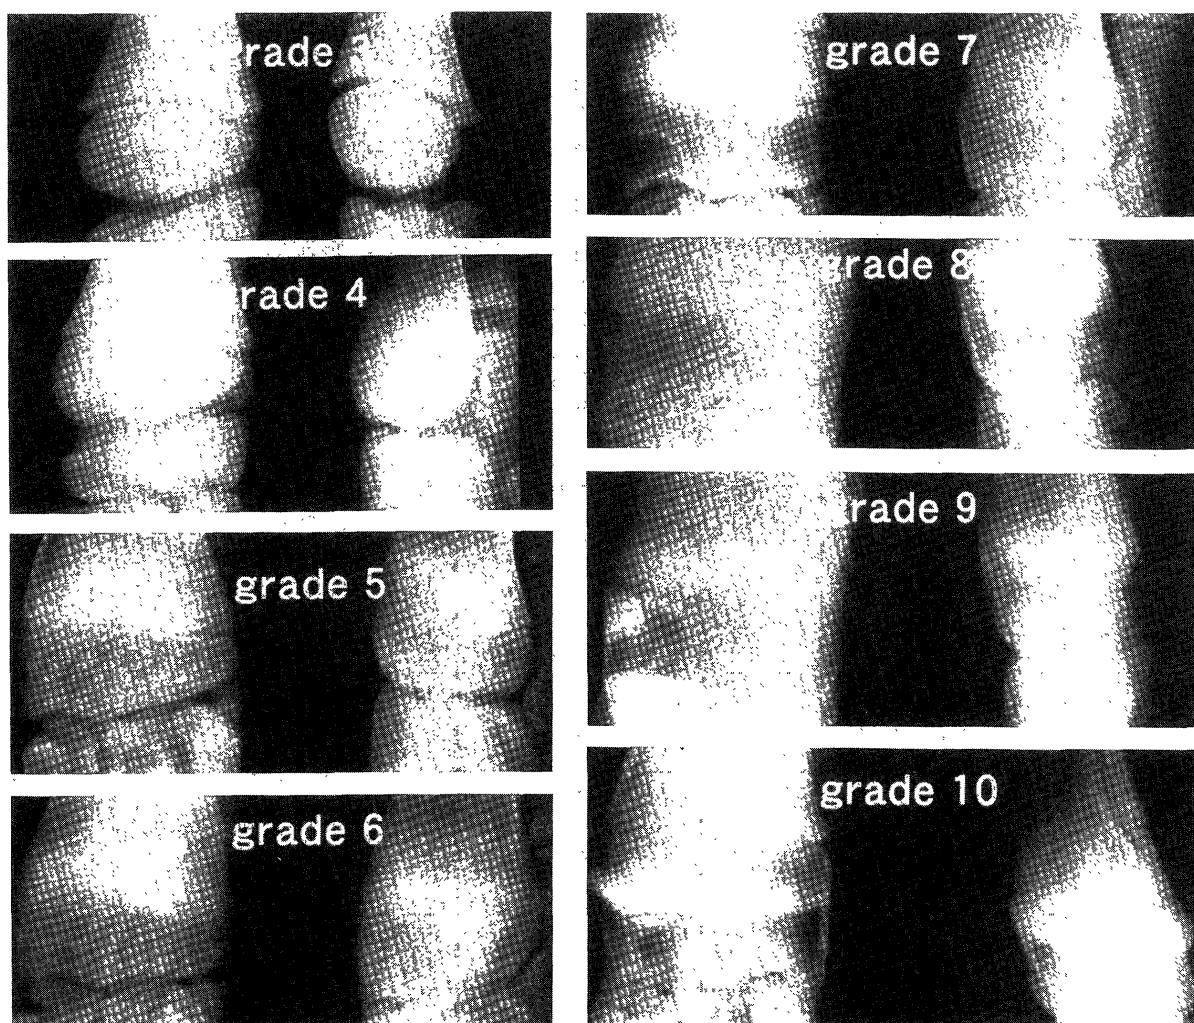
Radiographs of standard ossification in the distal radius immediately after birth, the ossification stage was grade 3 or 4. Grades 5, 6, 7, 8, 9 and 10 were found at 2–3, 4–5, 6–7, 8–15, 16–27 and 28–30 months of age, respectively.
